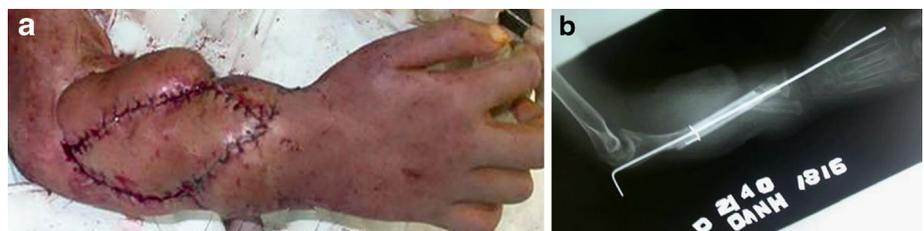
The forearm 1 year after the accident. Wound healing with a pedicle abdominal flap (a, b), both radius and ulna bones defects in X-ray (c)
